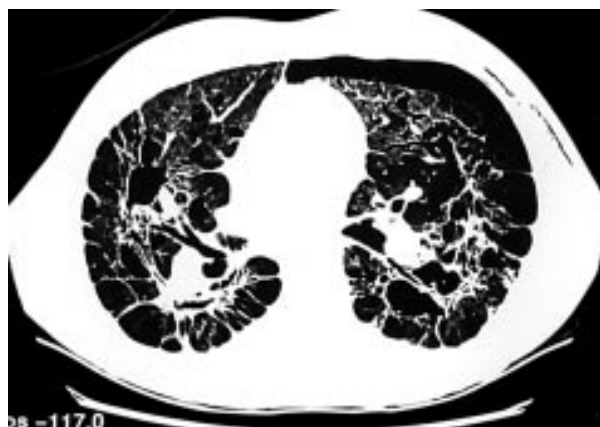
CT scan showing an anterior pneumothorax.
